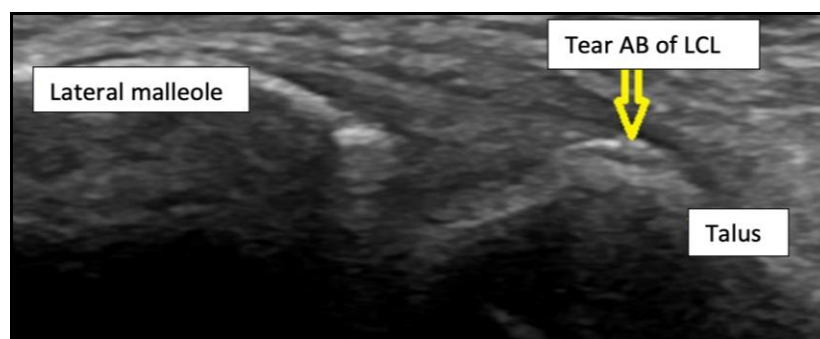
Ultrasound image of a tear in the anterior bundle (AB) of the LCL at its talar insertion
